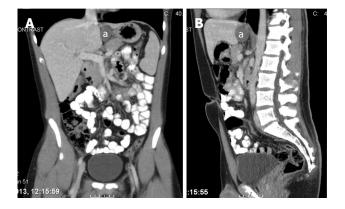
Computed tomography images of the esophageal duplication cyst (a). A: Frontal view; B: Sagittal view.
